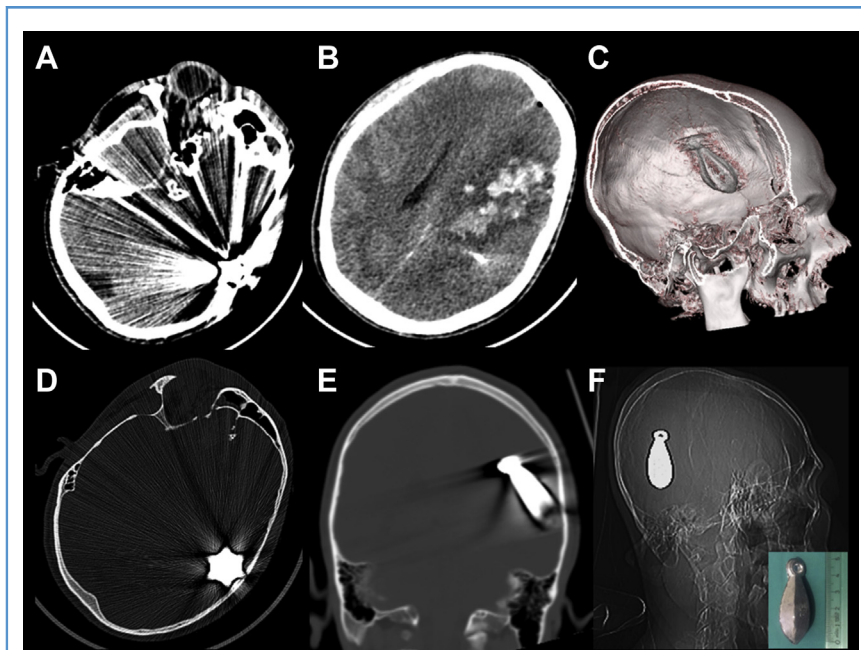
(A) Brain computed tomography (CT) image shows right orbital wall bone defect and metallic artifact of fishing sinker in the axial plane. (B) Brain CT image shows left intracerebral hematoma in the axial plane. (C) Reconstructed brain CT image shows the shape of fishing sinker and second position. (D) Brain CT image shows metallic artifact of fishing sinker in the axial plane, bone window. (E) Brain CT image shows metallic artifact of fishing sinker in the coronal plane, bone window. (F) Lateral-view roentgenograph shows the second position of intracranial fishing sinker and a photograph in the bottom right corner showing the fishing sinker.
